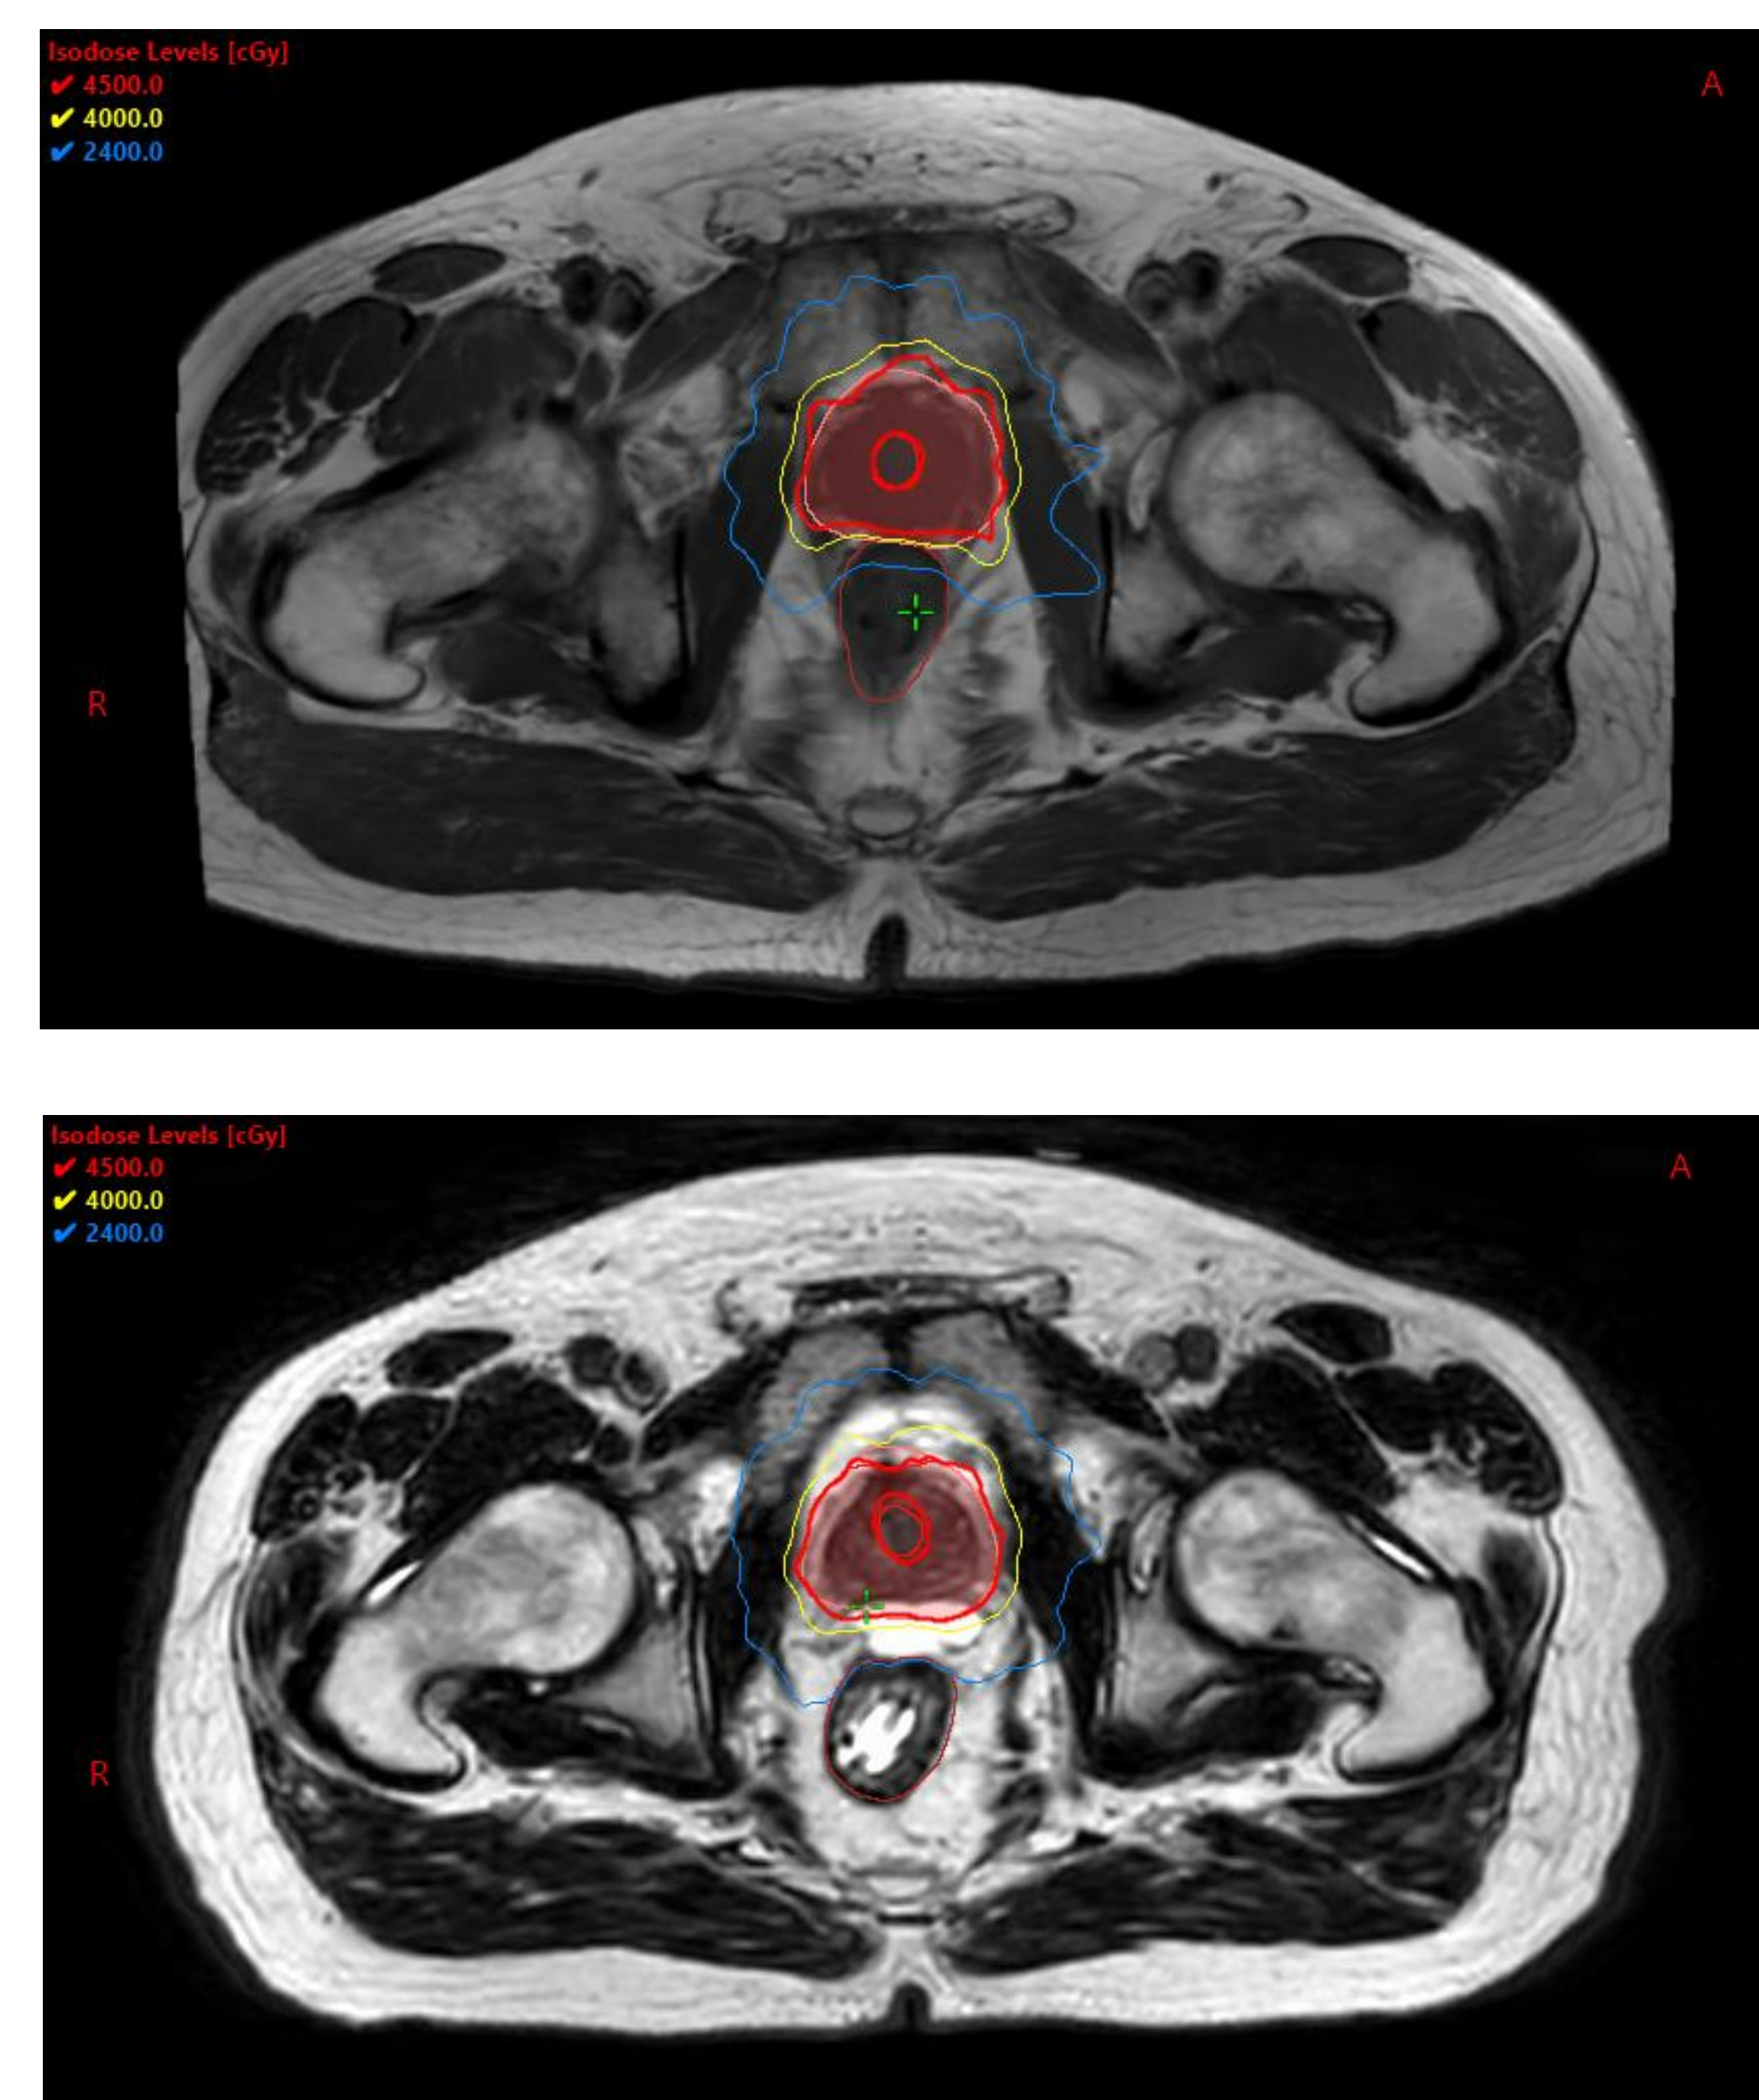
(Top) Reference SO-PRO plan, created on the diagnostic MRI and acquired prior to spacer. (Bottom) 1st fraction adaption, using the SO-PRO plan (above) as the reference plan. Note the inclusion of the spacer, visible on the T2 sequence. PTV is displayed in a solid pink color, isodose lines displayed are as follows: 45Gy (red), 40Gy (yellow), 24Gy (blue).
